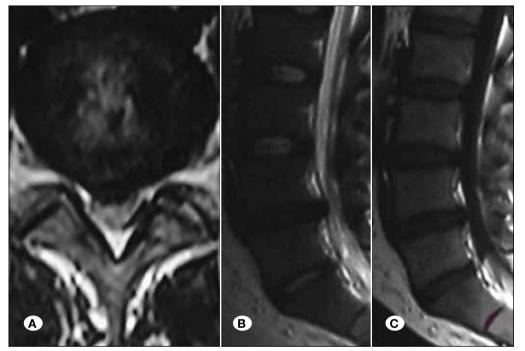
A) T2-weighted axial MR image that reveals central mass prolapse occupying more than 50% of the canal.
